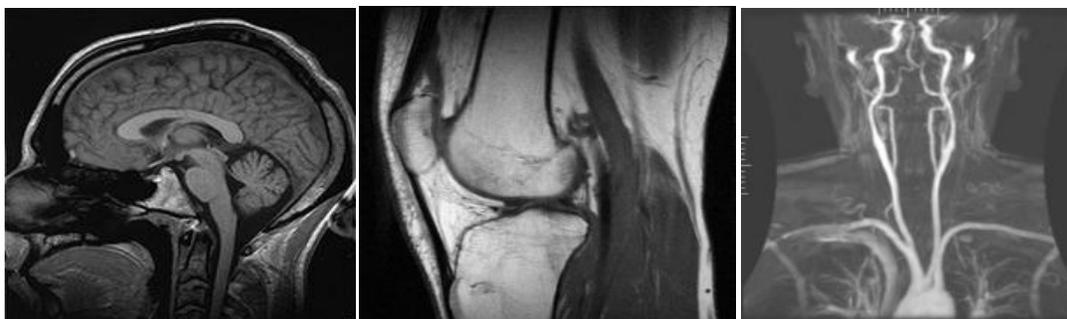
An MRI scan of a human head, knee and blood vessels of the aortic arch (carotid and subclavian) - examples of biomedical engineering application of electrical engineering to diagnostic imaging (<http://en.wikipedia.org>, 2011)
